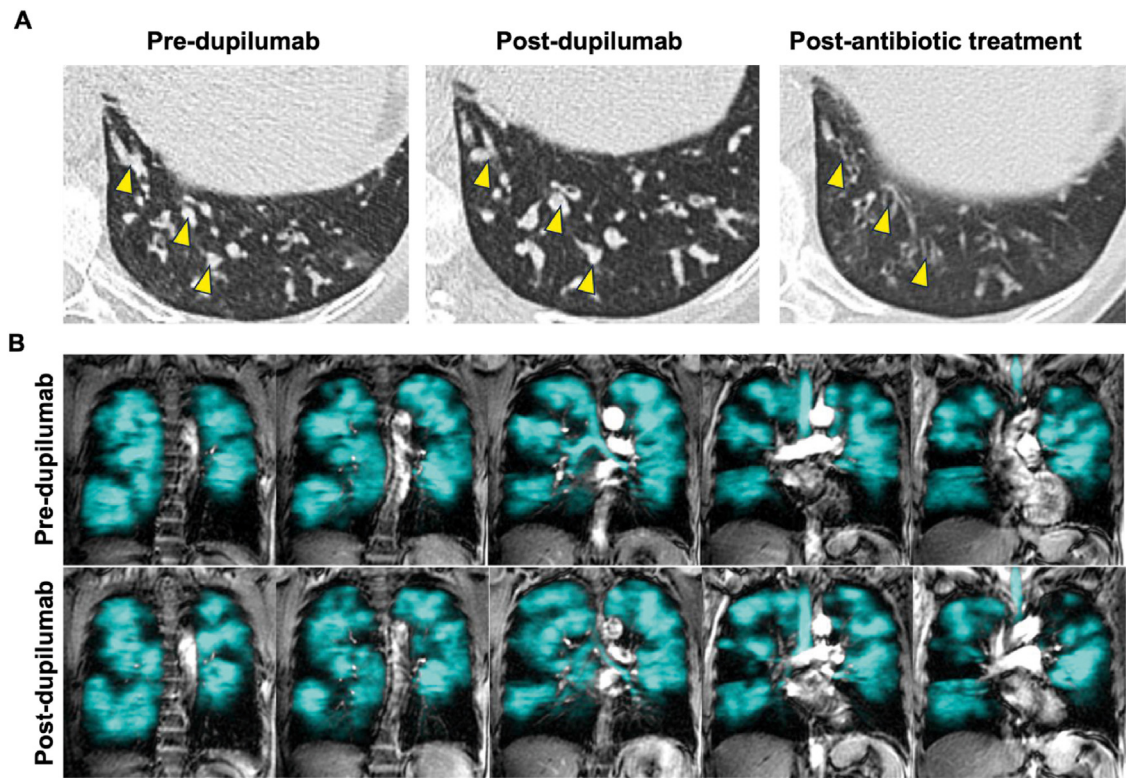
CT and MRI images of a patient with airway mucus who did not respond to dupilumab. Panel A shows three CT axial planes acquired before and after treatment with dupilumab (first and second images from left to right), and after prolonged antibiotic treatment (image on the right). The yellow arrows indicate the persistence of severe mucus plugging despite administration of an anti-IL4/IL-13-targeting biologic, suggesting that the significant burden of airway mucus was not driven by this mechanism. This finding correlated with the severe ventilation defects observed by ¹²⁹Xe MRI (Panel B), which were similarly unchanged between baseline and the end of treatment with dupilumab. A follow-up lung MRI correlating with the marked improvement in CT-mucus scores has yet to be acquired.
